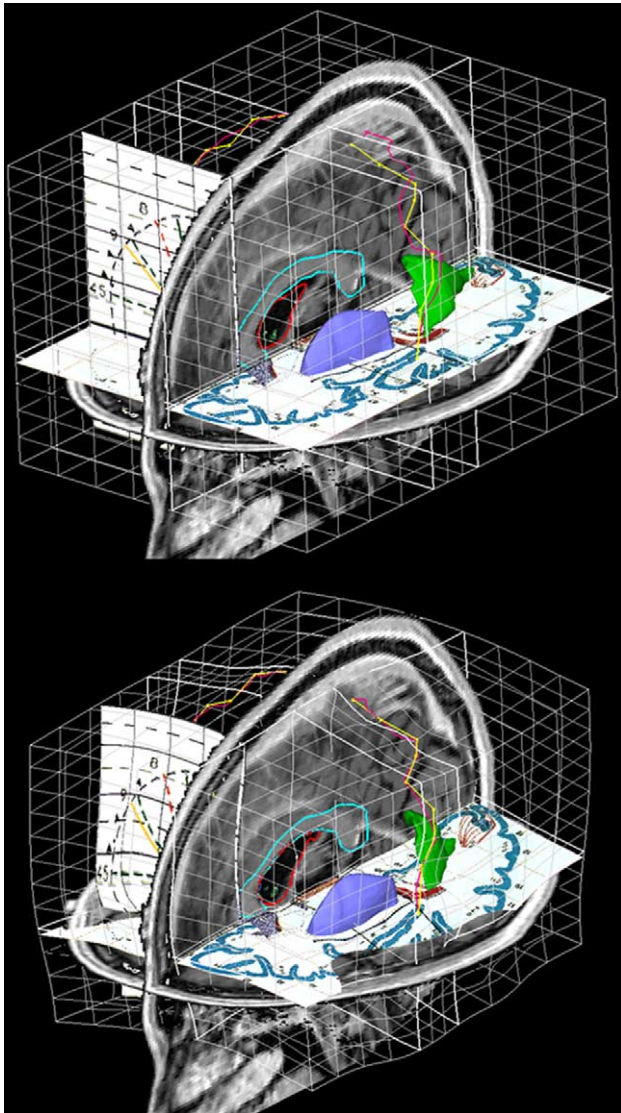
Several information entities of the digital Talairach atlas displayed in the context of a patient's MRI dataset. Top: situation after piecewise linear matching; bottom: situation after nonrigid matching. Two surface models are visible: putamen (blue) and tapetum (green). Object contours of the lateral ventricles (red loop) and the corpus callosum (cyan loop) are drawn on the sagittal MR cross-section. Two atlas plates (the axial one taken from the Talairach and Tournoux, 1988 atlas, the coronal one from the Talairach and Tournoux, 1993 atlas) and the proportional grid are displayed, too. (This figure is available in colour, see the on-line version.)
